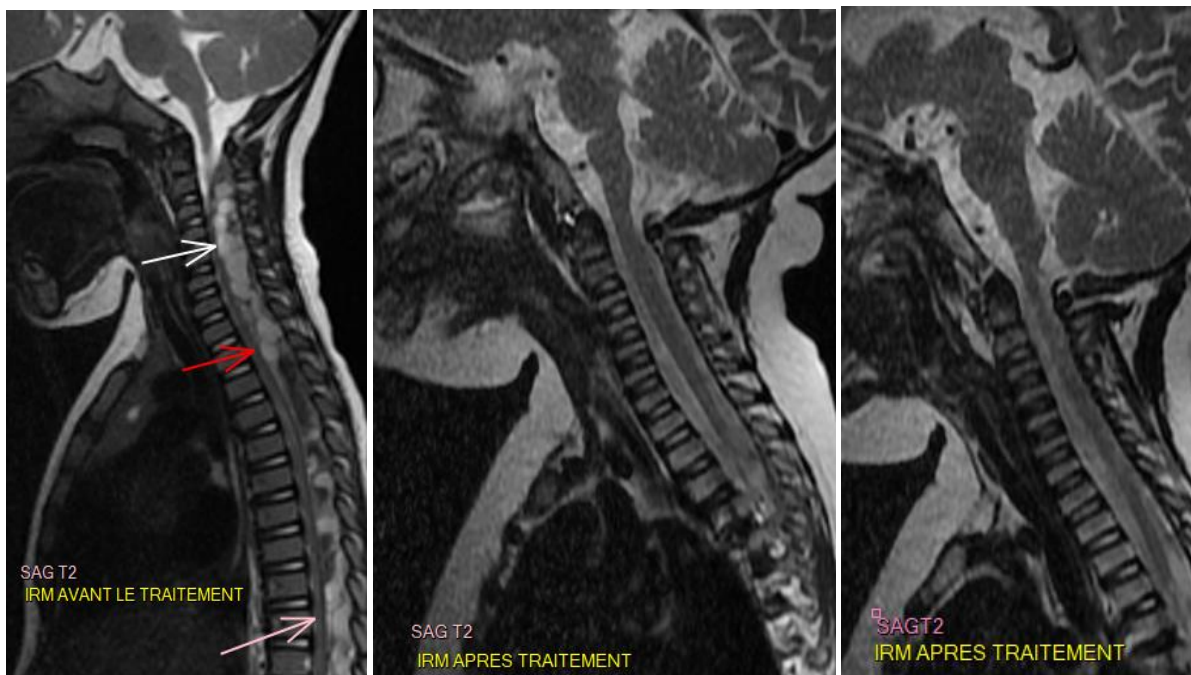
Sagittal T2-weighted spinal MRI scans taken before and after treatment, showing complete resolution of the hematoma after one month of treatment
